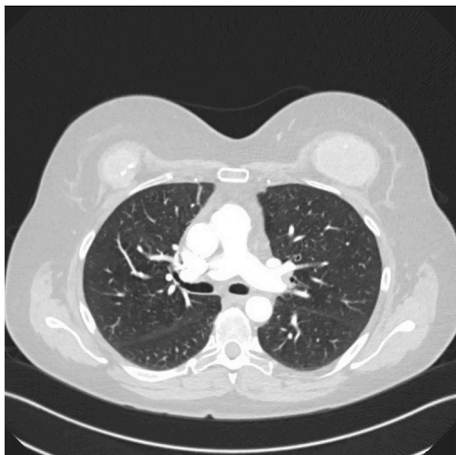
CT scan of lungs before removal of silicone breast implants.
